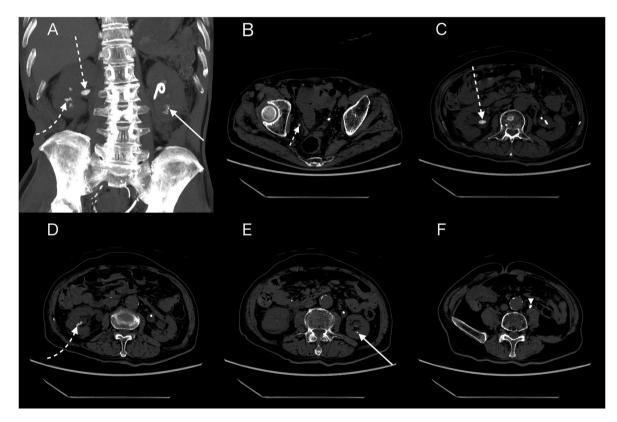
Coronal MIP images (A) and axial CT images (B–F) taken on the day of admission showed bilateral kidney stones (A, C, D, E), a right ureteral stone (B, short dashed arrow), and a left ureteral stone (F, arrowhead). Most of the stones had a hazy appearance (A-D, dashed arrows), except for two dense stones in the left kidney (A, E, white arrows) and left ureter (F, arrowhead).
